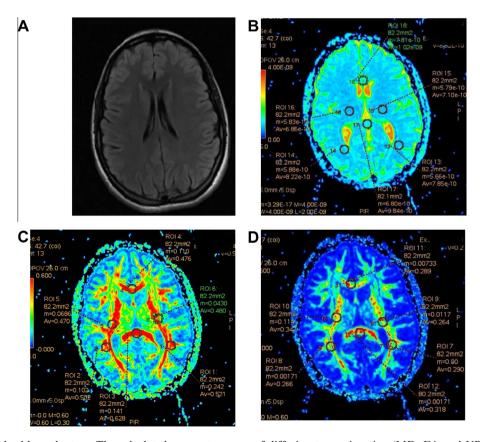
DTI of a healthy volunteer. The calculated parameter maps of diffusion tensor imaging (MD, FA and VR) reflecting normal values in Multiple ROI at corpus callosum, supratentorial normal white matter, posterior limb of internal capsule. In MD map the image contrast is defined by the different diffusivity of CSF and brain parenchyma. FA and VR maps reveal proper delineation of white matter tracts with a great variation throughout the brain due to differences in fiber direction and density with proper myelin sheath of axons. Highest anisotropy is seen in the genu and splenium of the corpus callosum. The contrast between regions of low and high anisotropy is stronger in VR map than FA. (A) Axial FLAIR image. (B–D) DTI directionally encoded color (B: MD, C: FA, D: VR) map (ROIs are placed in genu, splenium of corpus callosum and NWM.
